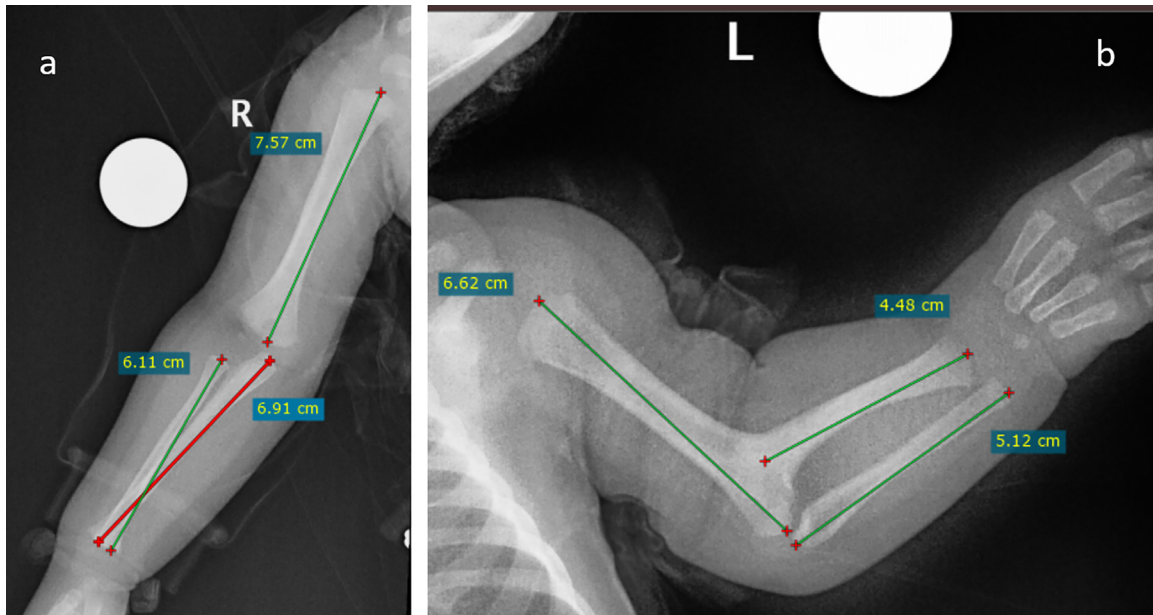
Two plain radiographs of the right (image A) and left (image B) upper limbs showing the reduced lengths of the left humerus, radius, and ulnar as compared to the same bones in the right upper limb.
